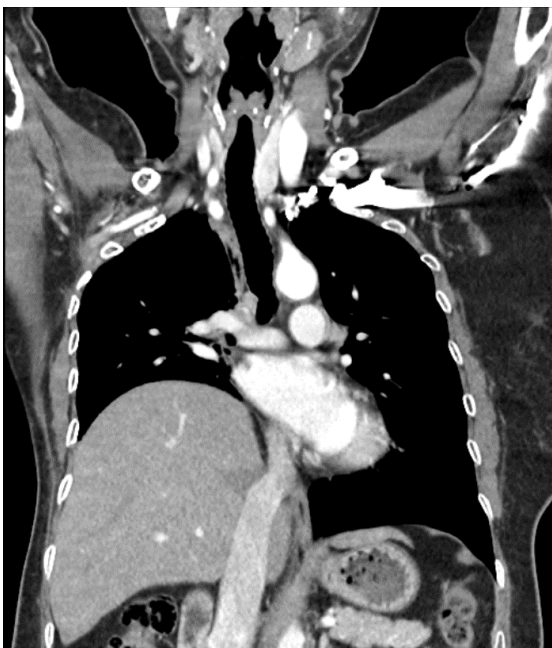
Computed tomography showed right diaphragm elevation.
